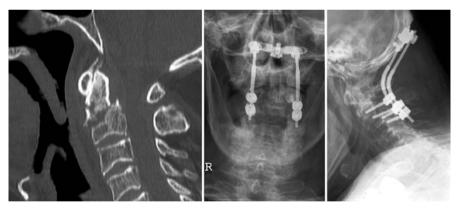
Cervico-occipital stabilisation for unstable odontoid type III fracture. Note anterior subluxation in preoperative CT, reduced in postoperative flexion X-ray
